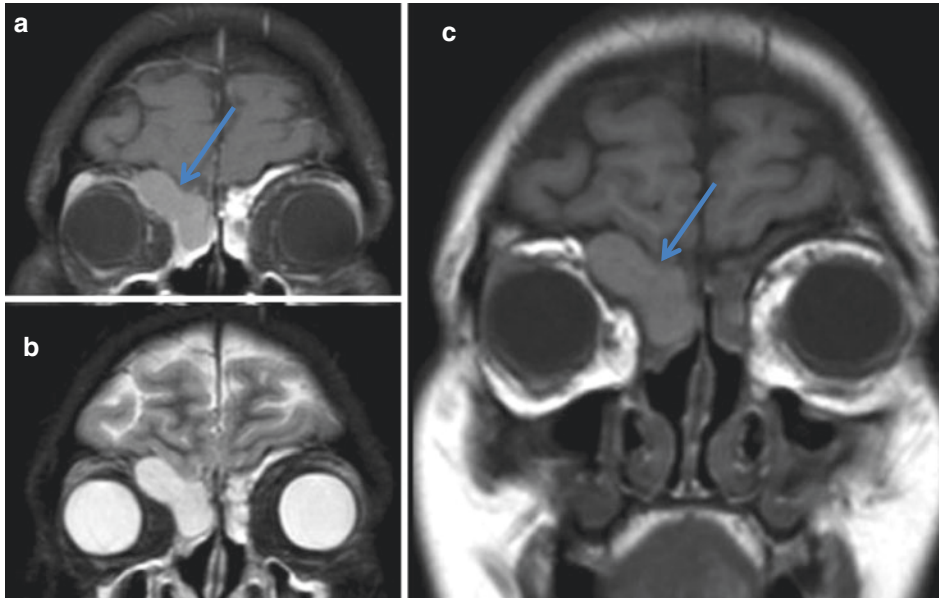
(a–c) Axial CT images of a patient who has had previous sinus surgery, demonstrating a right frontoethmoidal mucocele, with bony dehiscence at the superior-medial orbital wall and bulging into the orbit (blue arrows)
